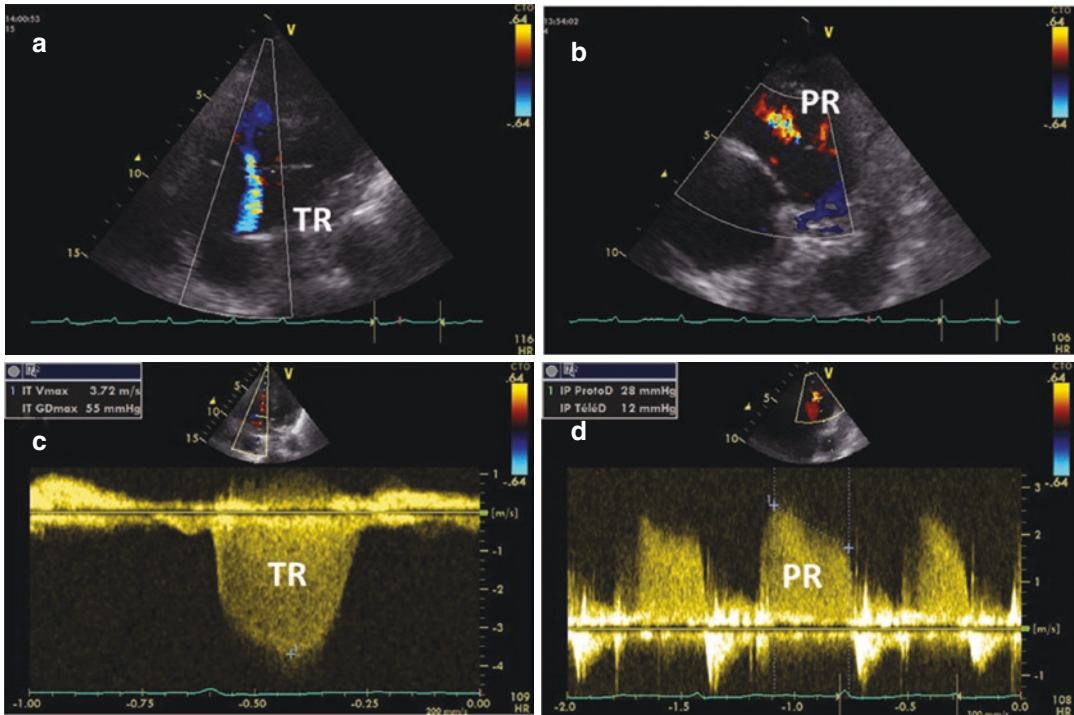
Pulmonary artery pressures. (a) Tricuspid regurgitation imaging (TR) with colour Doppler. (b) Pulmonary regurgitation (PR) imaging with colour
